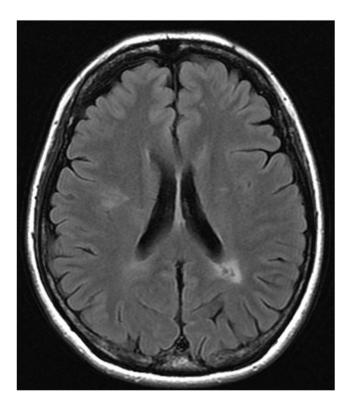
Brain MRI on this admission, with no new lesions.
